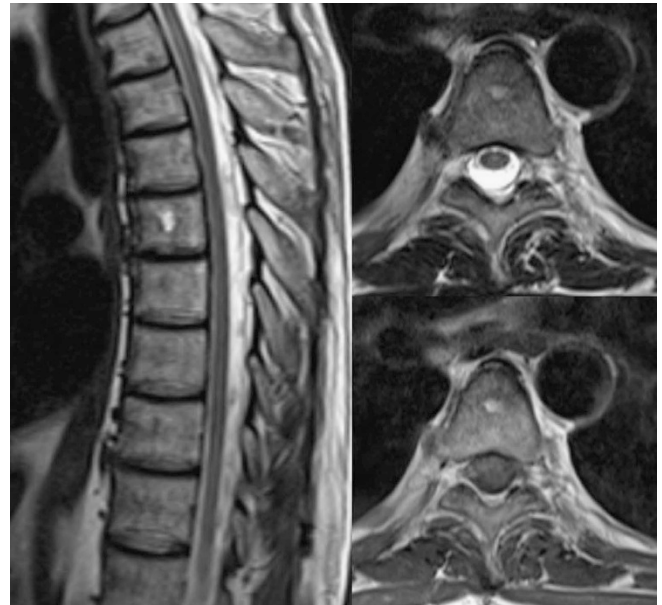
MRI of the thoracic spine after removal of the knife showing normal anatomy of the spinal canal and slight signal changes in the vertebral bodies consistent with edema and hemorrhage.
